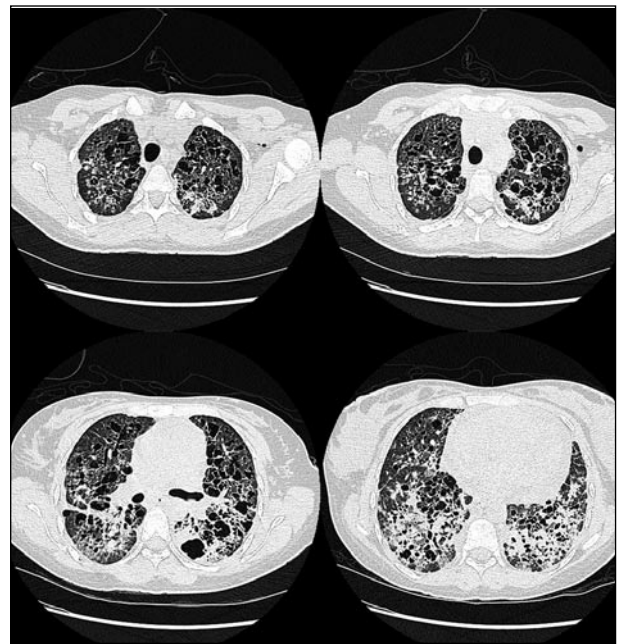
CT scan of the chest showing extensive bilateral diffuse interstitial changes, cystic lesions and multiple ill defined nodules
